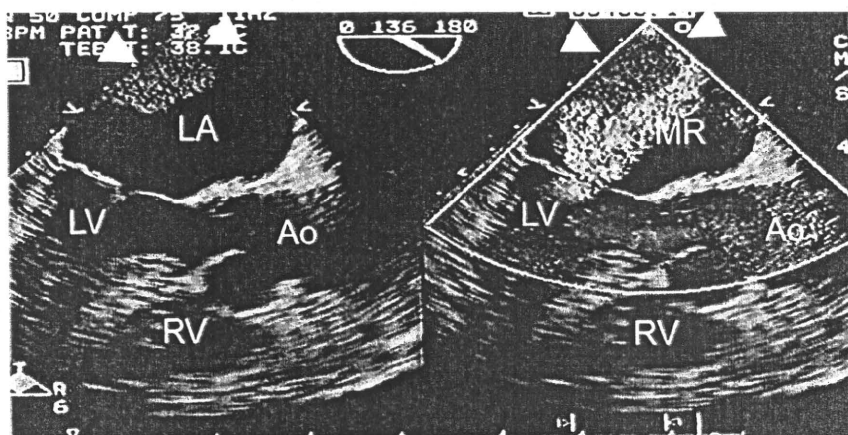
Trans-esophageal echocardiograms showing a recurrent giant thrombus (arrow heads) in the left atrium at the second admission regardless of severe mitral regurgitant jet. MR indicates mitral regurgitation.
